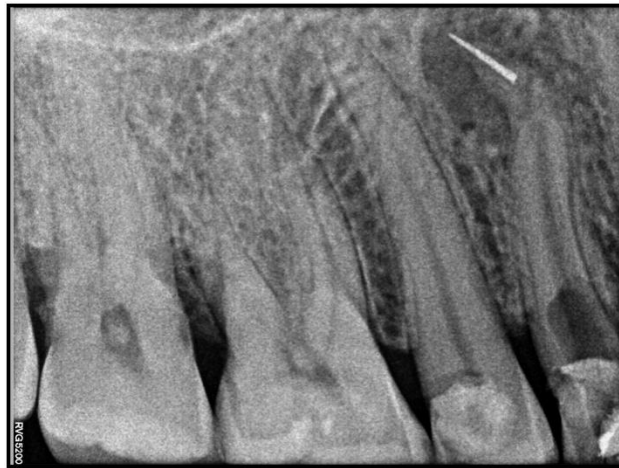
Radiograph showing fractured instrument beyond apex
